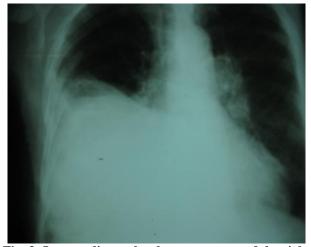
Lung radiography shows an ascent of the right diaphragmatic dome.
